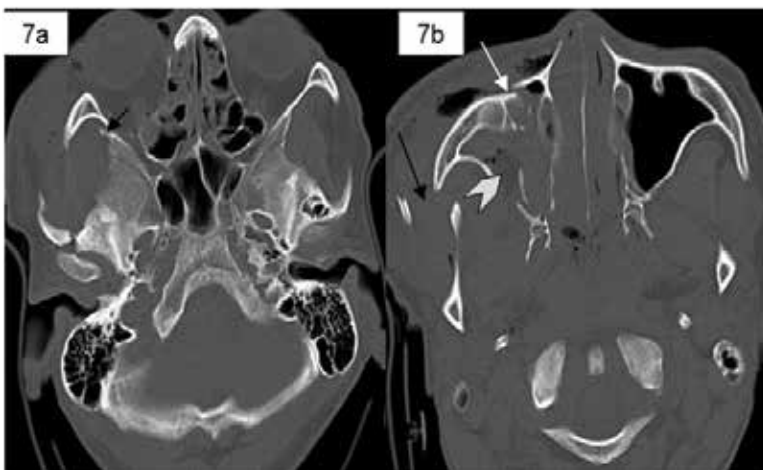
and 7b Contiguous 5-mm axial CT scans bone window demonstrate multiple bony fractures at right zygomatic arch (black arrow), anterolateral bony wall of right maxillary sinus (white arrow), right maxillary hemosinus (white arrowhead), and greater wing of right sphenoid bone (short black arrow).
